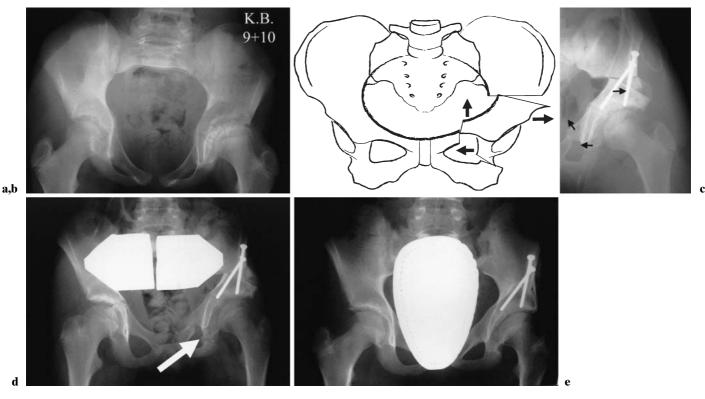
Triple innominate osteotomy. a Preoperative AP view of the pelvis in a child with hip pain and residual left hip dysplasia. b Nature of a triple innominate osteotomy. c Immediate postoperative radiograph after triple innominate
